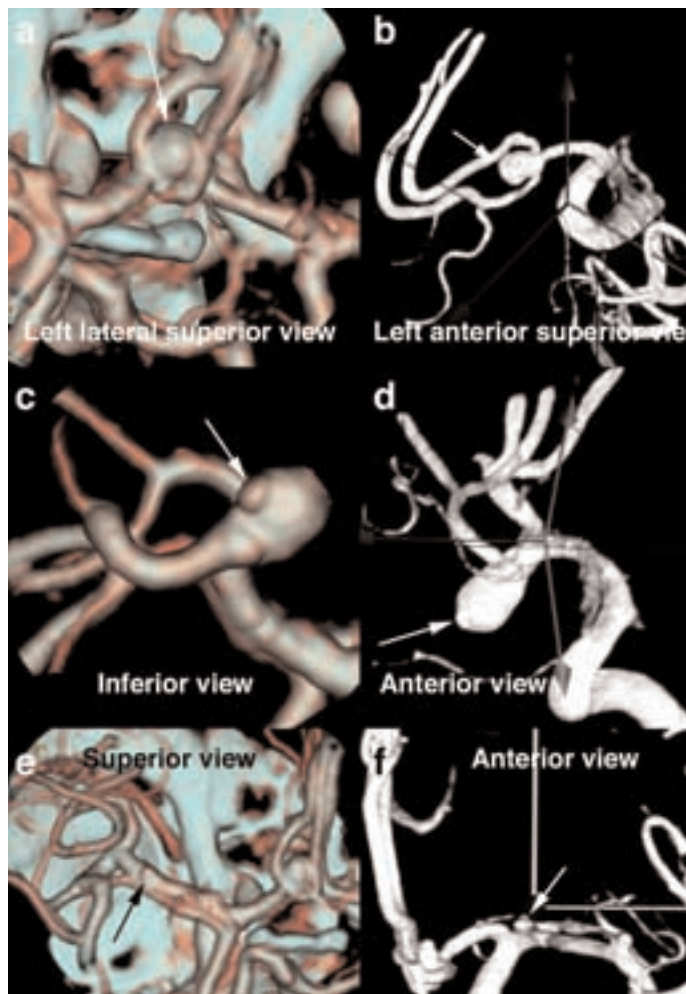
56-year-old female patient with unusual headaches but no subarachnoid hemorrhage. CTA 3D SSD views (a,c,e) and 3D DSA (b,d,f) both correlate in demonstration of 4-mm left anterior communicating artery aneurysm (sac/neck ratio of 1 to 1.4, arrows) (a, b) and an 8 x 5-mm aneurysm at right sylvian bifurcation (sac/neck ratio of 1 to 1.4) (c,d), showing small accessory inferior lobulation (arrows). On the other hand, 3D DSA (f), but not conventional DSA, depicts 1.5-mm aneurysm on superior aspect of left M1 segment (arrow). Aneurysm (e) was visible on admission CTA as very tiny outpouching (arrow) but prospectively considered as an arterial wall irregularity rather than as a true aneurysm by the two reviewers.
